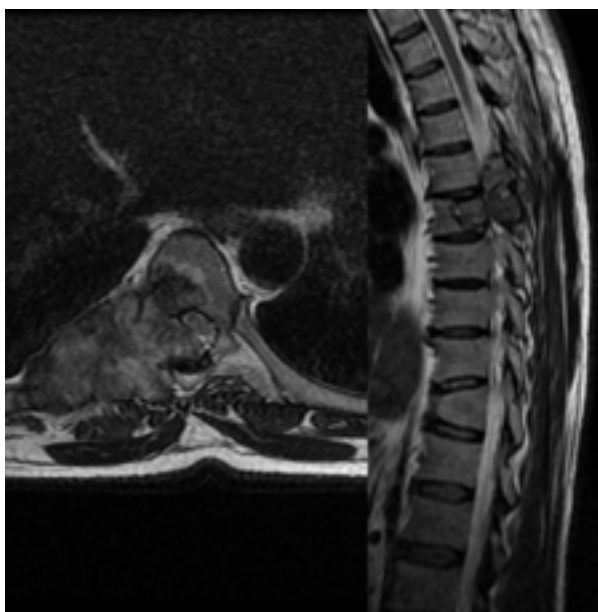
T2A axial and sagittal sections of pre-operative MRI. A mass destroys the right costovertebral angle at the level of the T7 vertebra, showing infiltration in the right transverse process/intraarticular facets, and compressing the spinal cord.
